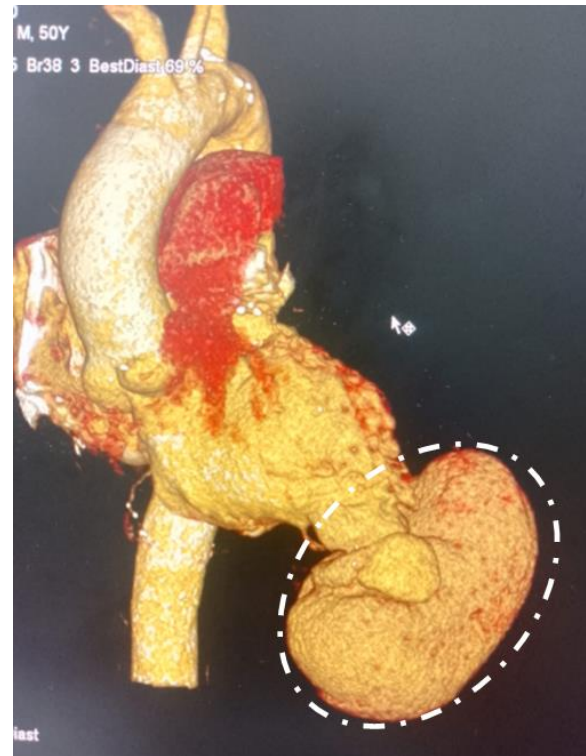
Showing Cardiac CT images demonstrating huge LV apex pseudoaneurysm
